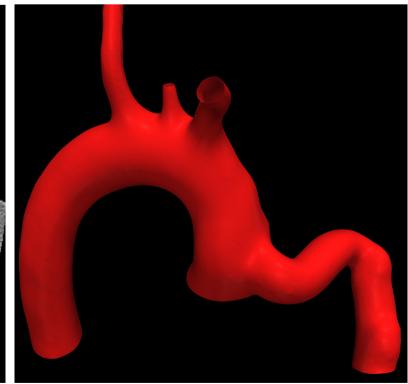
Left: CT-scan slice at the anastomosis site between outflow cannula of the LVAD (IC) and the aorta (Ao), Right: Reconstructed geometry.
